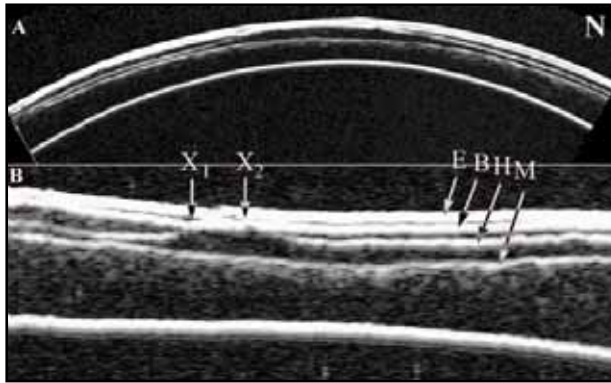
Geometrically corrected horizontal VHF digital ultrasound corneal B-scan of a cornea 1 day after recutting a second flap and obtaining a simultaneous separation of the original flap from the bed and a buttonhole (A). An axially zoomed image in a different horizontal plane is shown below (B). The surface of epithelium (E), Bowman's layer (B), the keratectomy produced by the second-cut Hansatome 160-head (H), and the original Moria keratectomy interface (M) are labeled. The Hansatome interface is seen to course superficially to the original keratectomy as intended from left to right, but superficializing, exiting through Bowman's (X1) and the epithelium, then re-entering the epithelium and crossing Bowman's (X2) to again find a plane superficial to the original keratectomy. Exact anatomical apposition of Bowman's is confirmed by the scan, thus confirming perfect flap repositioning and minimizing the probability of epithelial ingrowth in the visual axis.
